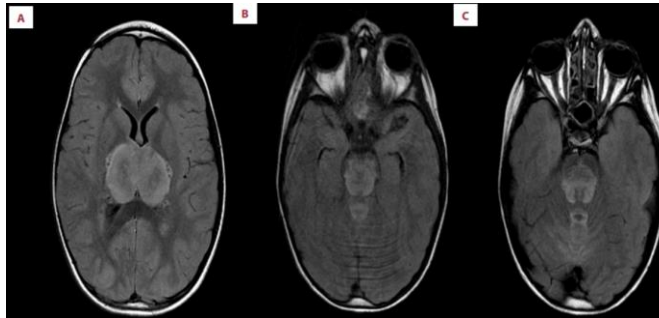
Brain MRI FLAIR Sequence showing widespread brainstem lesion (midbrain) with microhemorrhage with necrosis.
